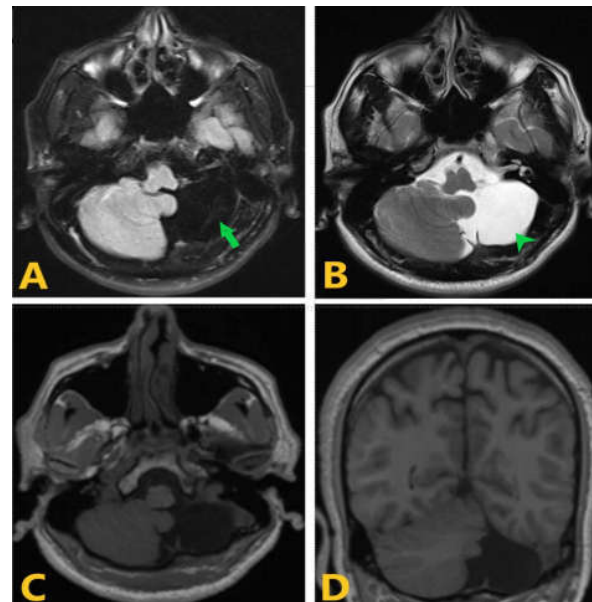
Magnetic resonance imaging of Brain plain shows hypodensity in fluid attenuated inversion recovery sequence (A) (arrow), T1 weighted axial (C) and coronal (D) sections and hyperdensity in T2 weighted image (arrow head) suggestive of aplasia.
